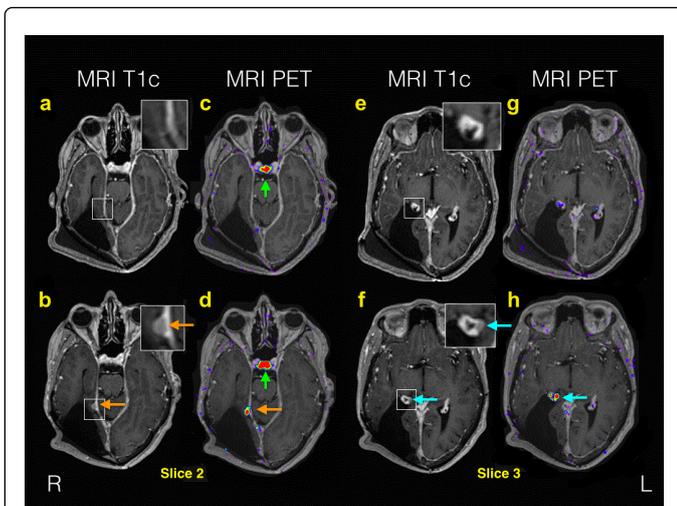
Post-contrast T1-weighted MRI images alone and fused with ^{68}Ga -DOTATOC PET at stereotactic radiotherapy planning (2a, 2c, 2e, 2g, top) and after 11 months (2b, 2d, 2f, 2h, bottom). At clinical routine MRI follow-up a 3 mm in diameter recurrence at the right tentorial edge was identified (2b, orange arrow) that was not identifiable 11 months previously (2a) confirmed by ^{68}Ga -DOTATOC PET (2c). However, MRI did not locate a 2 mm in diameter recurrence buried in the right choroid plexus (2f, cyan arrow) clearly identifiable with ^{68}Ga -DOTATOC PET (2h, cyan arrow). Green arrow points to physiological ^{68}Ga -DOTATOC uptake in the pituitary gland. The relative level of slices 2 and 3 and recurrences are labeled in MIP (1f). Orientation: R: Right; L: Left; A: Anterior; P: posterior.
